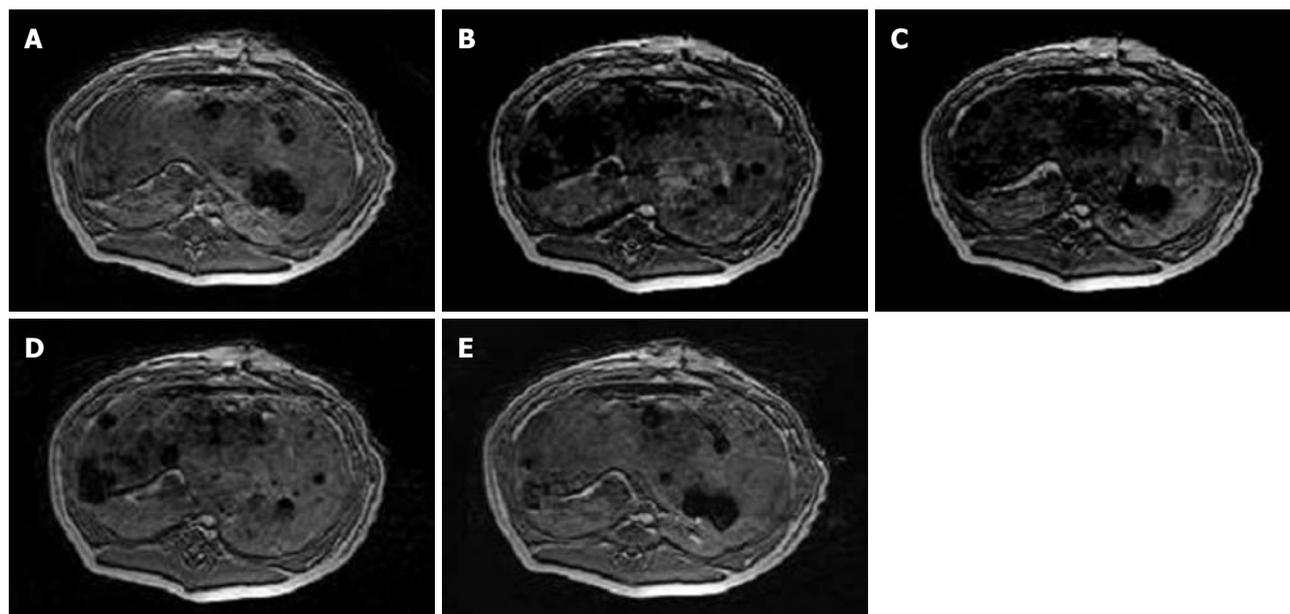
Magnetic resonance imaging of Feridex-poly-l-lysine labeled mesenchymal stem cells in the liver. A: No loss of signal in the liver before transplantation; B: Significant signal intensity loss was observed in labeled mesenchymal stem cells on FFE sequences 6 h after transplantation; C, D: Attenuation of signal loss appeared over time; E: T2*-weighted images gradually approached to the normal level at the endpoint of the study.
